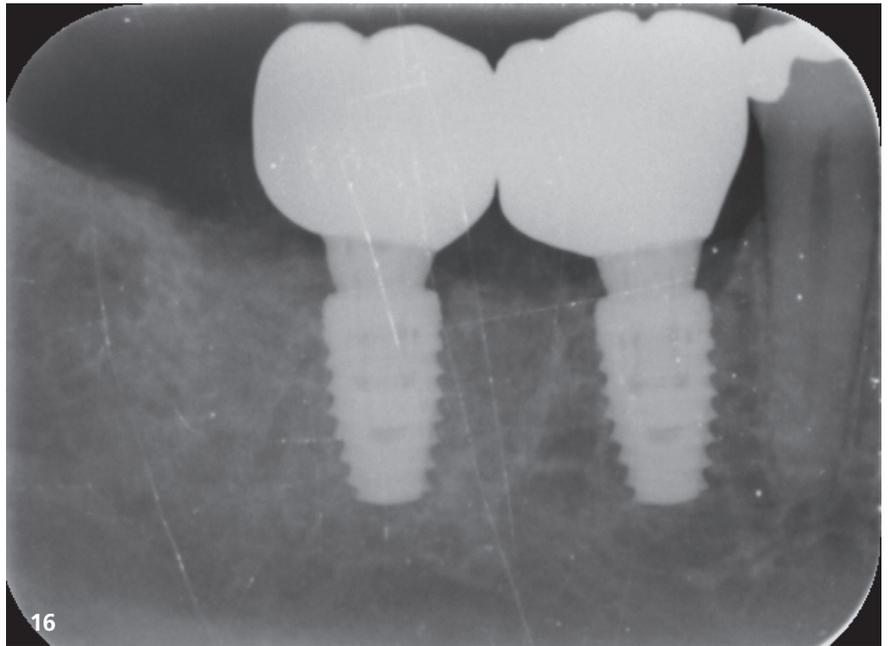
Post-restoration radiograph.
